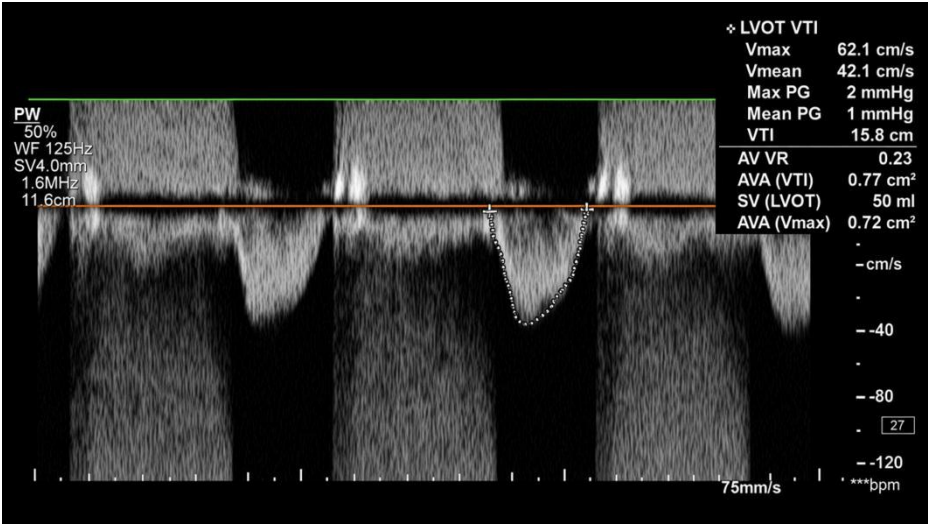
Pulsed-wave Doppler of the left ventricular outflow tract (LVOT VTI).
